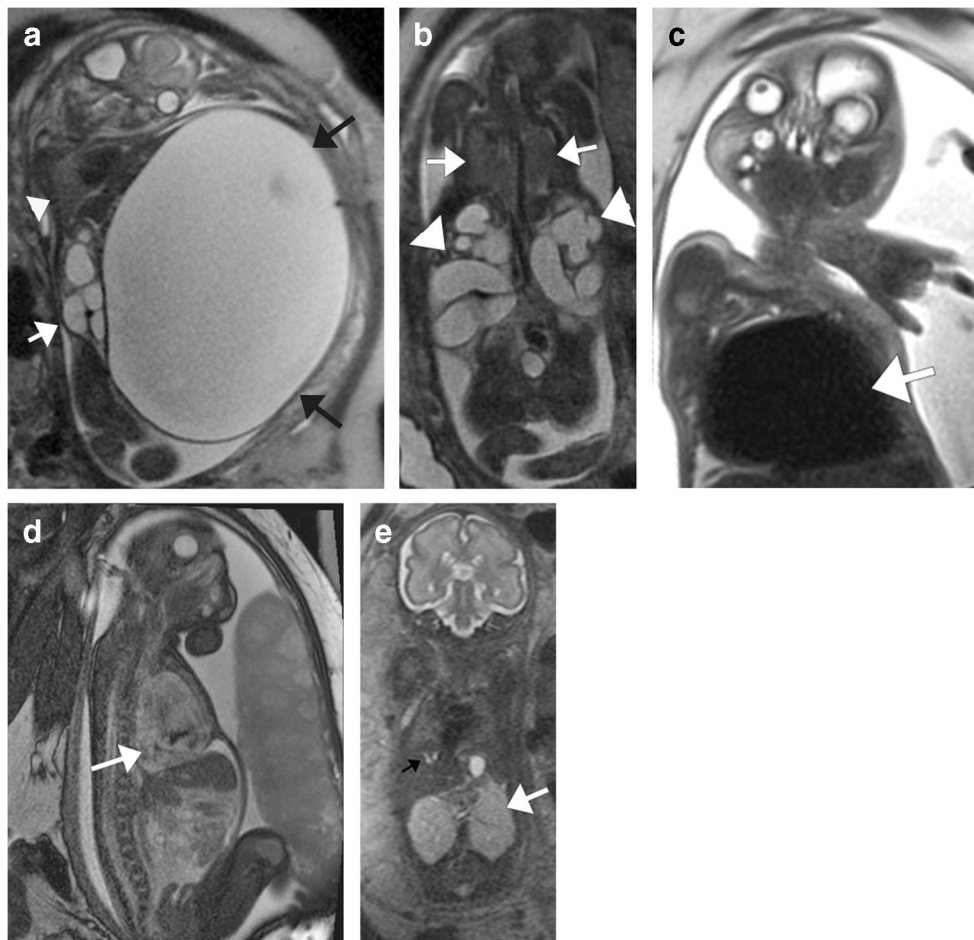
Examples of pulmonary hypoplasia. a, b Sagittal (a) and coronal (b) single-shot turbo spin-echo (SSTSE) MR images in a 22-week fetus with markedly enlarged bladder (*black arrows* in a) shows findings of pelviciectasis and marked ureterectasis (*white arrow* in a, *arrowheads* in b), marked pulmonary hypoplasia (*arrowhead* in a, *arrows* in b) and oligohydramnios. Together with a small colon (not shown) in this female fetus, the findings were consistent with megacystis microcolon intestinal hypoperistalsis syndrome. c, d Coronal black-blood SSTSE (c) and sagittal steady-state free precession (SSFP) white-blood (d) sequences of the thorax in a 33-week fetus with Ebstein anomaly (*arrows*). Note
